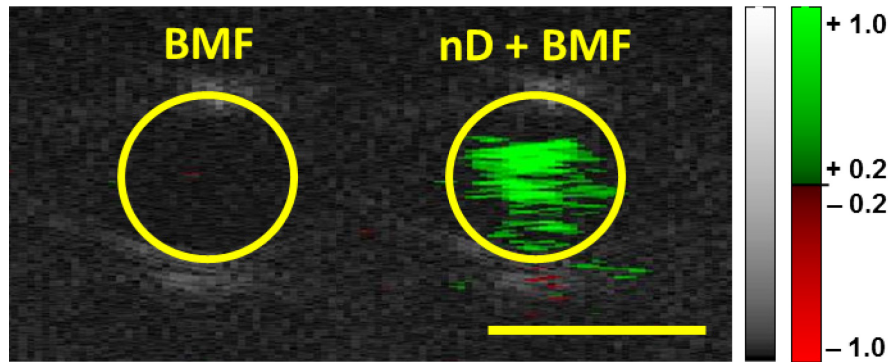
Flash-difference images using multi-angle pulse inversion image sequences. Two tubes (shown as yellow circles) were placed 2 cm deep in tissue mimicking gelatin. The tubes were subjected to a 500 cycle at 1.2 MI ultrasound and the contents were flowing at 20.0 mL/min. Yellow scalebar represents 5 mm. The gray and red-green colormap represents ultrasound signal before the HIFU pulse and the percent change in ultrasound signal after the HIFU burst, respectively [35].
